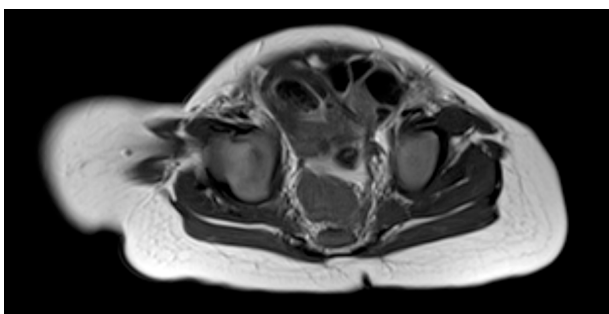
Abdomino-pelvic MRI (3 months old).
